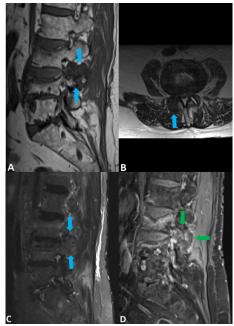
Magnetic resonance imaging of the lumbar spine (Siemens Magneton Symphony™, A - T1 sagittal, B - T2 axial, C - T2fs sagittal, D - T1fs axial, after intravenous administration of gadolinium) revealed lobulated lesion adjacent to the right L3-L4 facet joints (blue arrows). The lesion was markedly hypointense on T1 (A), with a predominantly hypointense signal on T2 (B and C) and with peripheral enhancement on dynamic study (green arrow in D).
